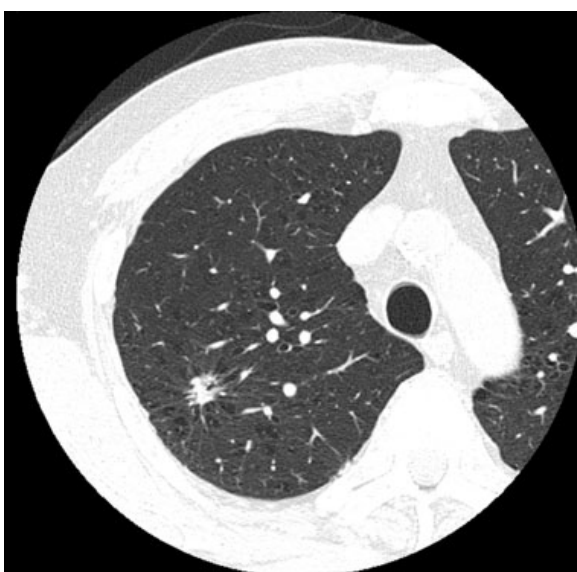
Chest CT with lung window, axial scan, showing a 10 mm spiculated nodule in the upper lobe of the right lung.
